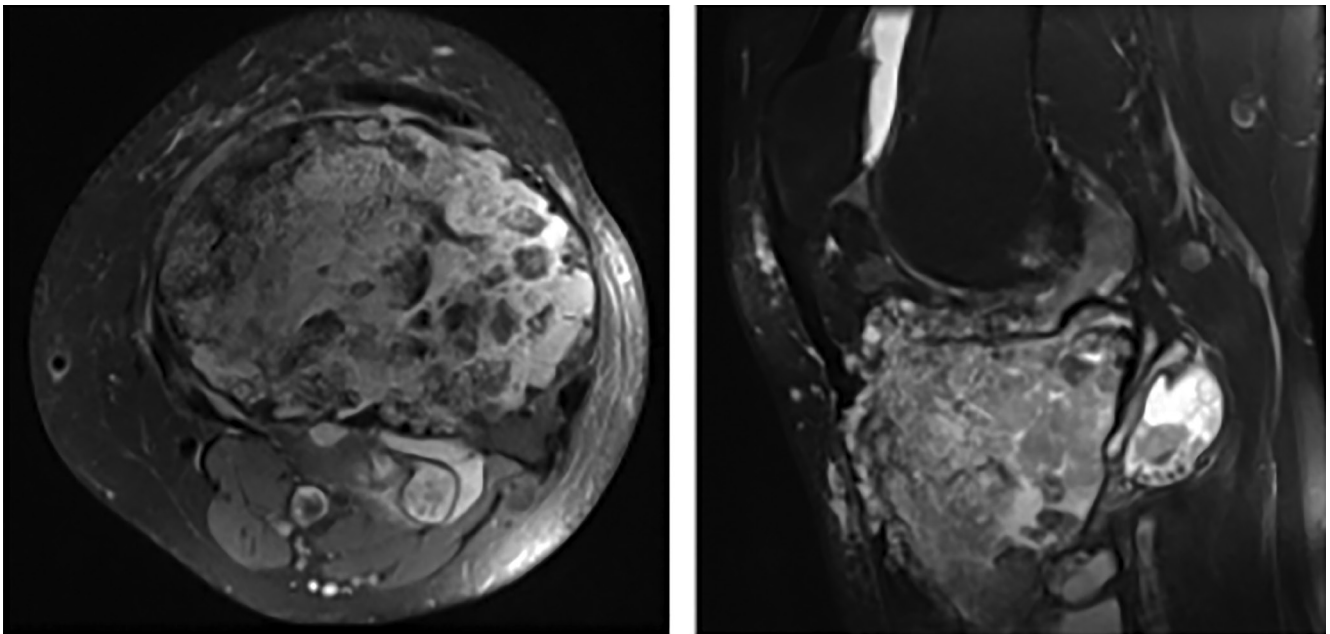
Subsequent magnetic resonance imaging (MRI) was conducted to further characterize the lesion. Axial (A) and sagittal (B) T2-weighted MRI sequences revealed a large, cystic lesion localized at the epiphyseal-metaphyseal junction of the proximal tibia. The lesion exhibited characteristic internal septations, focal chondroid-like calcifications, and prominent soft-tissue infiltration extending beyond the bone marrow cavity into surrounding musculature and adipose tissue. These radiological findings strongly supported the initial clinical suspicion of chondrosarcoma, necessitating further staging investigations.
